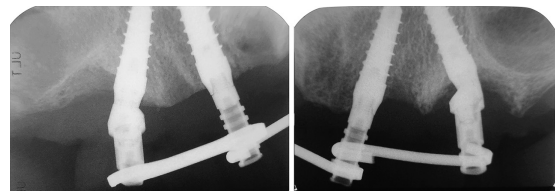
Radiographic images after delivery of provisional prostheses (TO).
